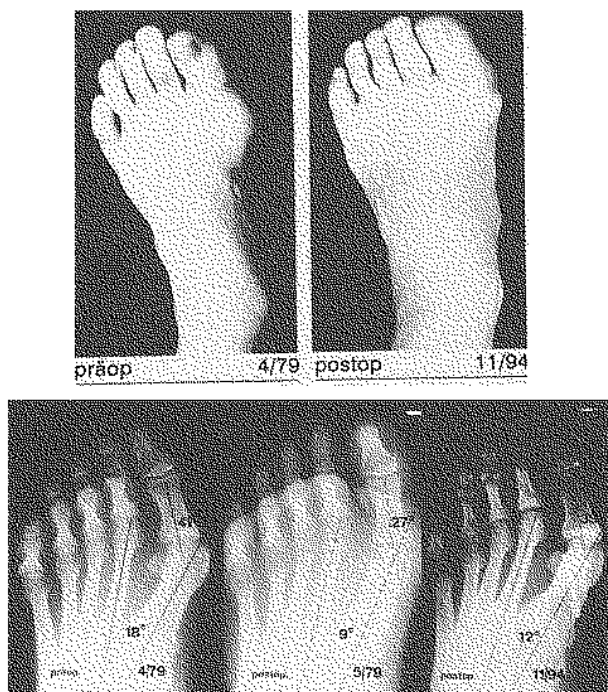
Dissatisfying result after Mitchell osteotomy : pre- and postoperative clinical appearance and radiographs.
